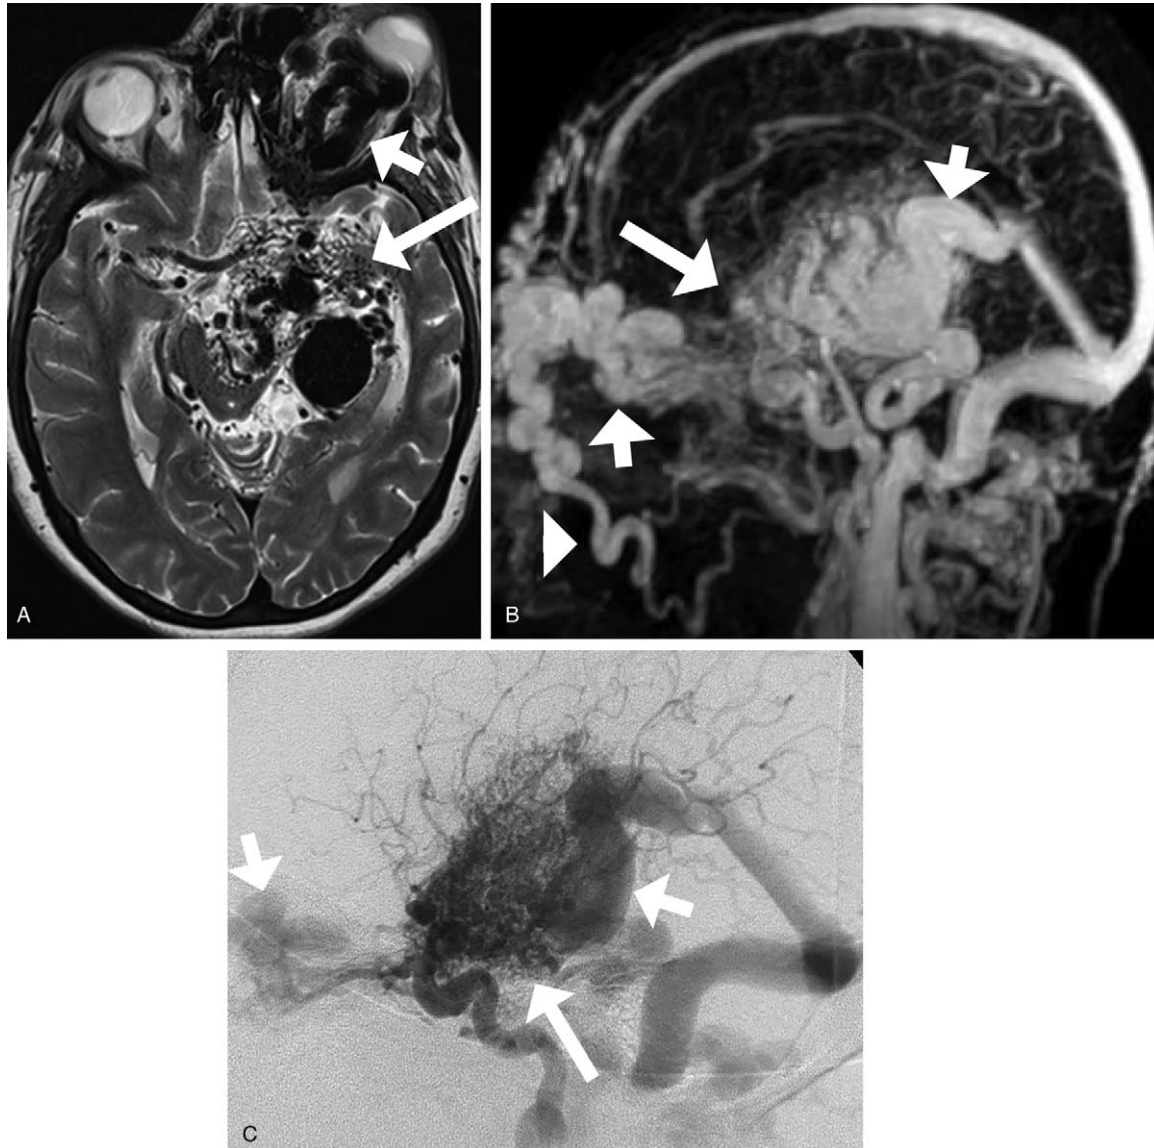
28-Year-old woman with Wyburn-Mason syndrome. Axial T2-weighted (A) image shows a large high-flow AVM involving the left optic apparatus including the left orbit (short white arrow), left optic nerve, optic chiasm and also the temporal lobe (long white arrow). Sagittal magnetic resonance venography image (B) shows the high-flow AVM involving the left optic apparatus (long white arrow) with venous drainage to the superior ophthalmic vein and to the deep venous system (short white arrows). There is also retrograde opacification of the left facial vein (white arrowhead). Digital cerebral angiography (C) shows the high-flow AVM involving the left optic apparatus (long white arrow) with venous drainage to the superior ophthalmic vein and to the deep venous system (short white arrows). Courtesy of Dr. Marcos M. B. Negreiros, Botucatu, Brazil.
